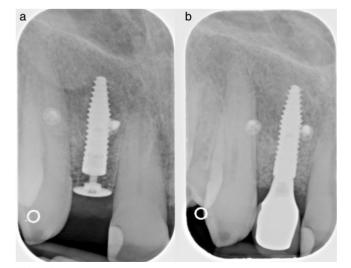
14a and 14b. Radiographic appearance of implant at baseline and 12 months after surgery.
